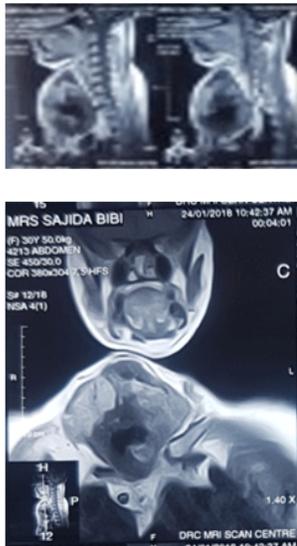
MRI: In M.R.I, a 12.5 x 12.0 x 7.9 cm mass was observed, from the root of neck to the anterior superior mediastinum. There was no metastasis (Figure 3).
